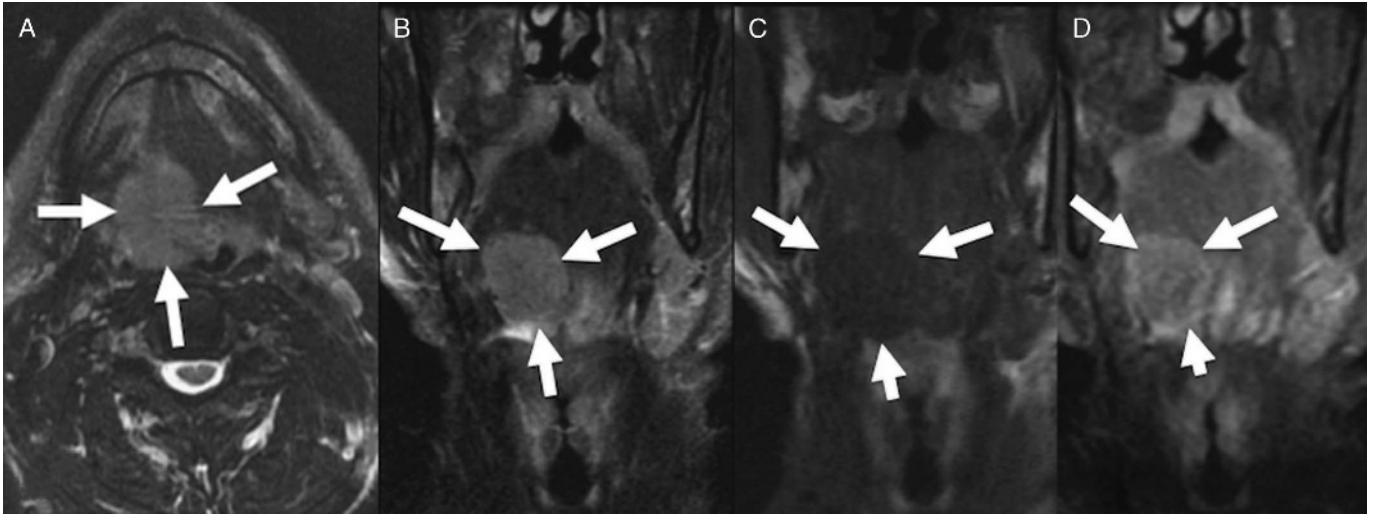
Follow-up MRI was obtained through the neck for further evaluation of the PSMA abnormality. Axial T2 (A), coronal T2 (B), coronal T1 precontrast (C), and coronal T2 postcontrast (D) MRI images demonstrate a large mass in the base of the right tongue (white arrows). Biopsy revealed invasive nonkeratinizing squamous cell carcinoma. ^{68}Ga -PSMA-11 is an investigational agent, which has been recently introduced for imaging patients with prostate cancer and shows promising results.¹⁻⁴ Whereas most PSMA imaging has been performed in prostate cancer, PSMA expression has been described in nonprostate malignancies such as breast cancer and primary gliomas,⁵ with recent case reports of [^{68}Ga]PSMA-11 uptake in breast carcinoma,⁶ clear cell renal cell carcinoma,⁷ hepatocellular carcinoma,⁸ and primary lung adenocarcinoma.⁹ The case presented here demonstrates that ^{68}Ga -PSMA-11 PET/CT can detect head and neck squamous cell carcinoma. Our case further highlights that PSMA is not as specific as originally believed and uptake can be found in many other types of neoplasms⁵⁻¹⁵ as well as benign pathologies.¹⁶⁻¹⁹
